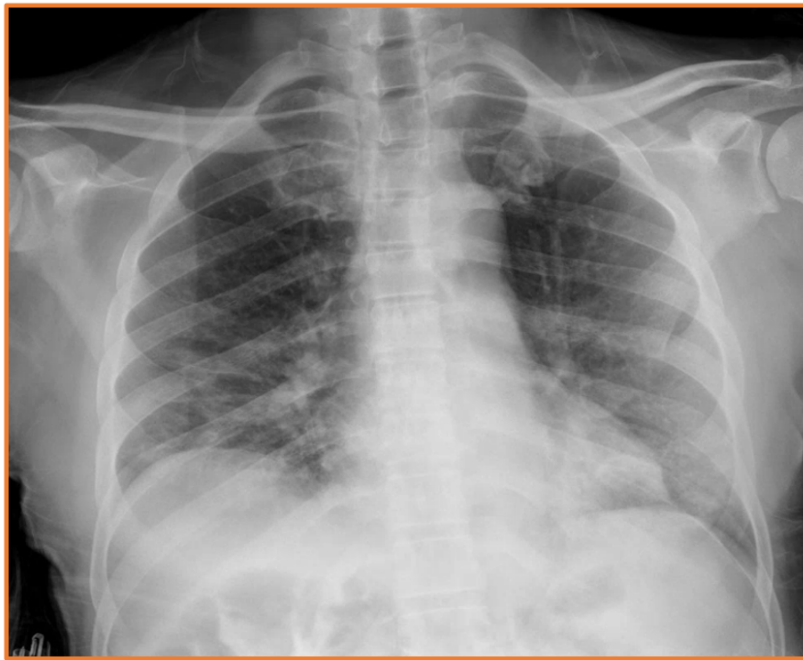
Chest X-ray showing hazy bibasilar opacities consistent with multifocal pneumonia
